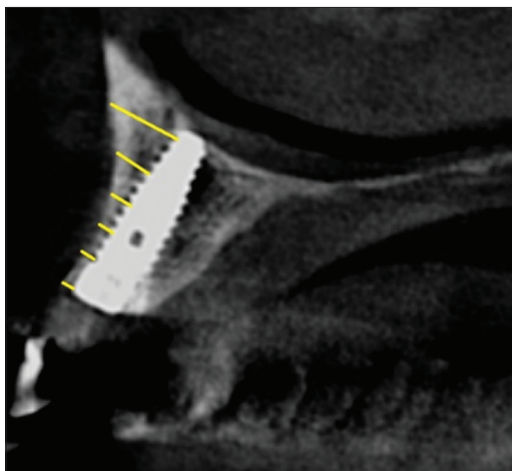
Horizontal dimension (HD), CBCT radiographic presentation
